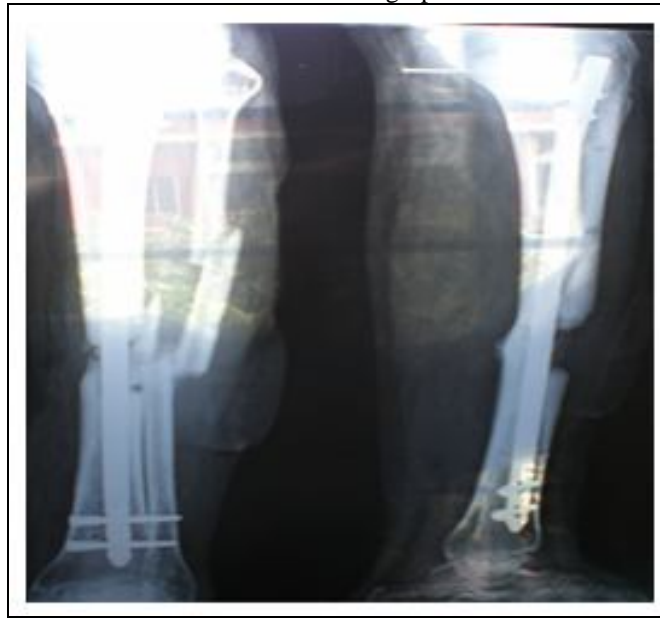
Post operative x-ray of a patient having Gustilo type IIIB wound
